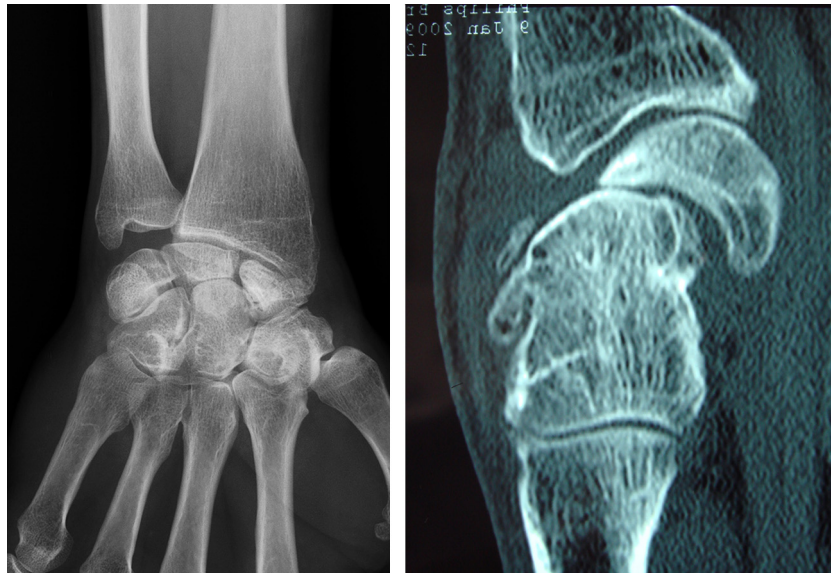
Antero-posterior radiograph of an SNAC wrist, which seems to be stage III. Computed tomography showed degeneration of the radiolunate joint space indicating stage IV SNAC wrist.
